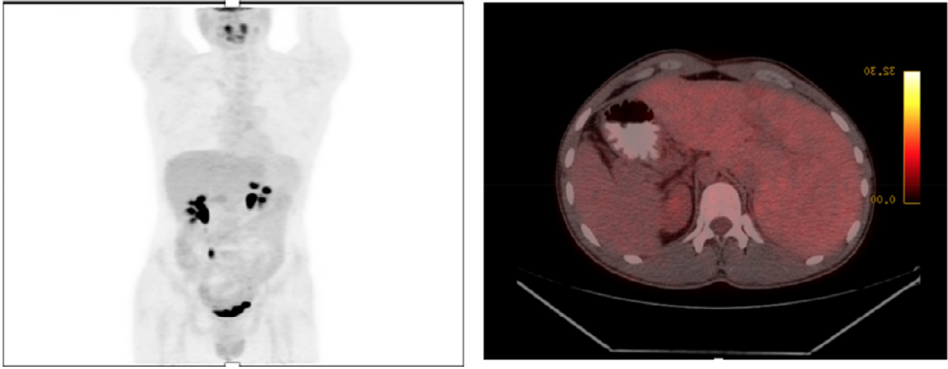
The last FDG-PET/CT of case 4 performed on November 2019, with no metabolically active lesion appears.
